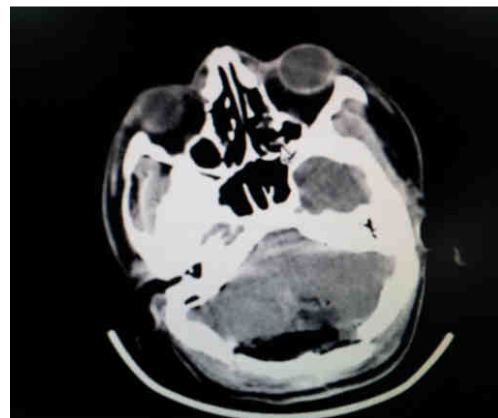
Post-operative computed tomography scan showing complete excision of lesion
